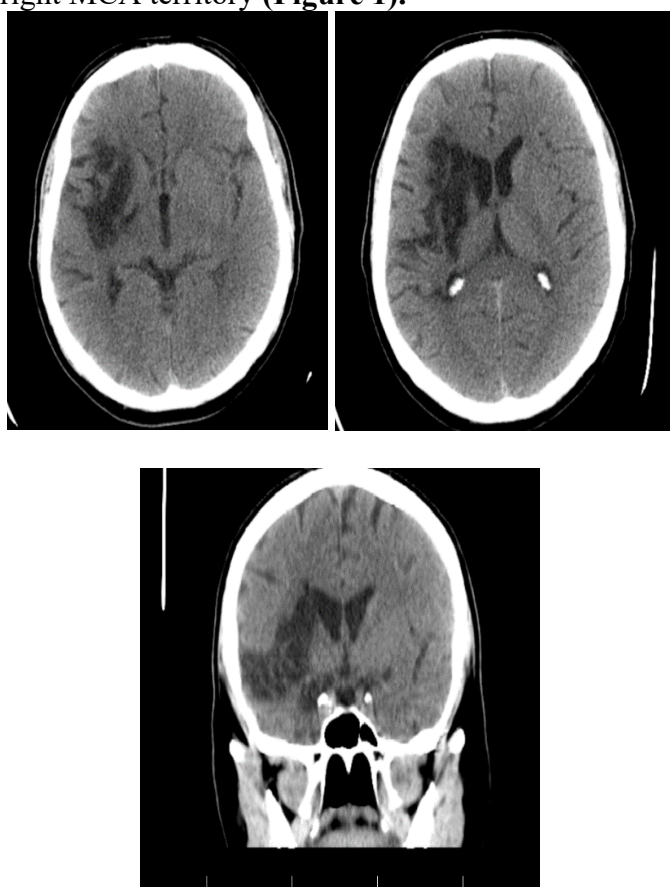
Native CT scan 6 weeks after stroke onset showing chronic ischemic area in the territory of the right MCA
